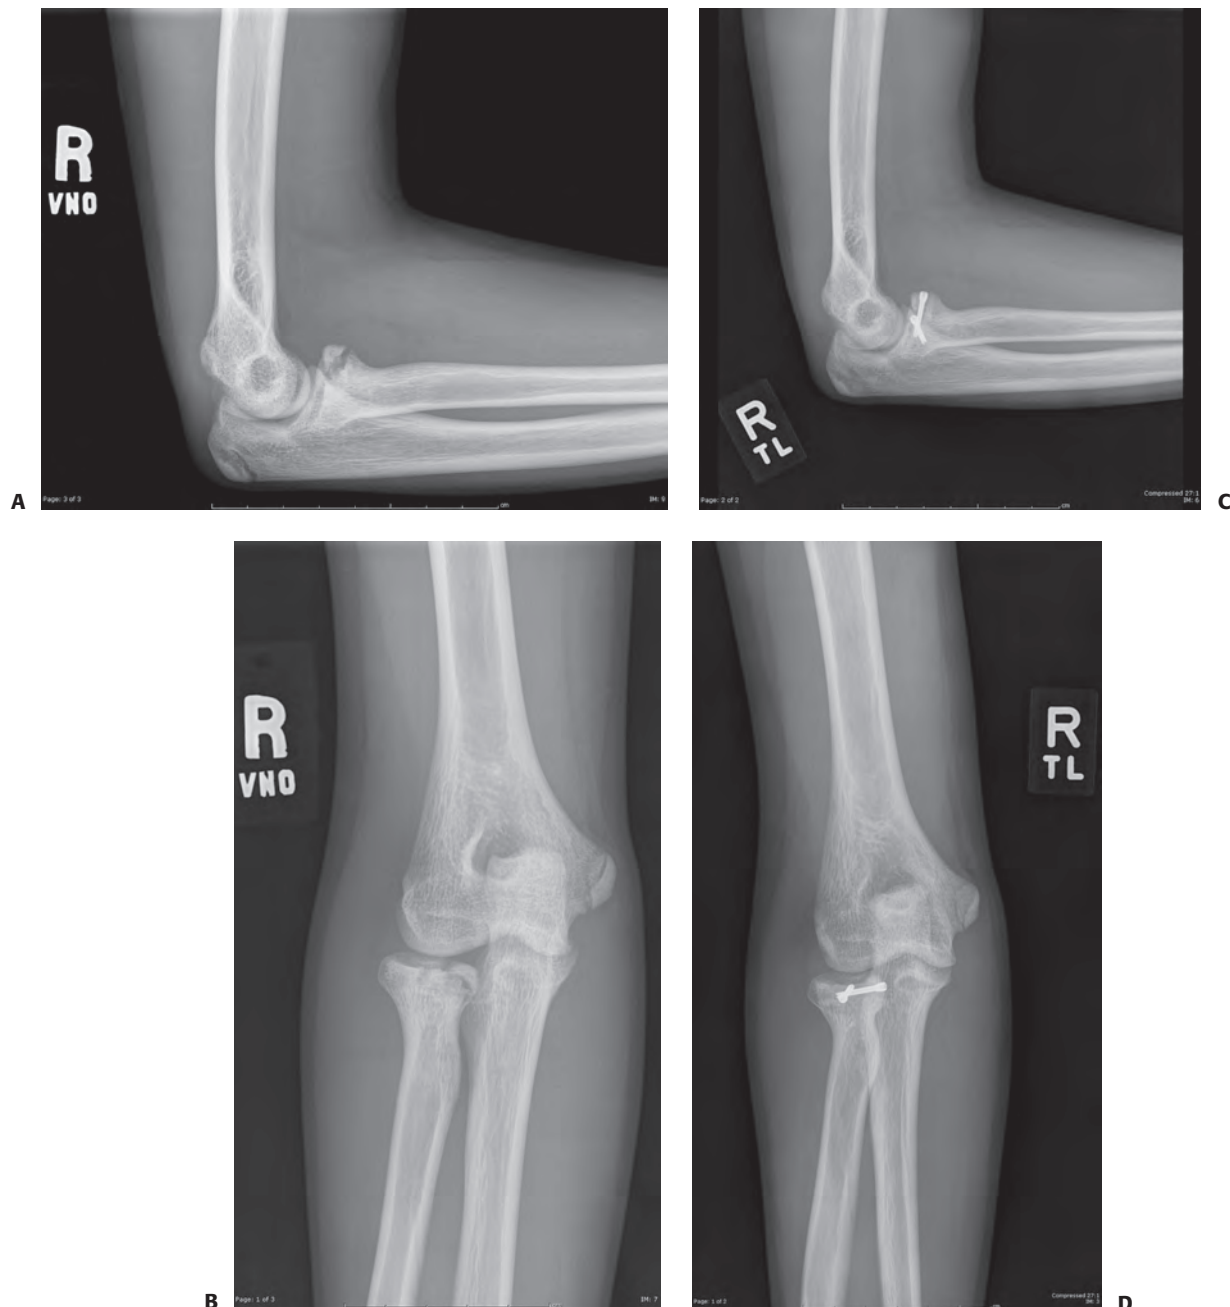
Nonunion of intra-articular radial head fracture. This 15-year-old female presented 1 year after elbow injury because of persistent pain (A). AP radiograph demonstrating nonunion of the radial head fracture (B). Lateral radiograph after open reduction and internal fixation (C). AP radiograph after open reduction and internal fixation (D). Lateral radiograph of the same patient.
